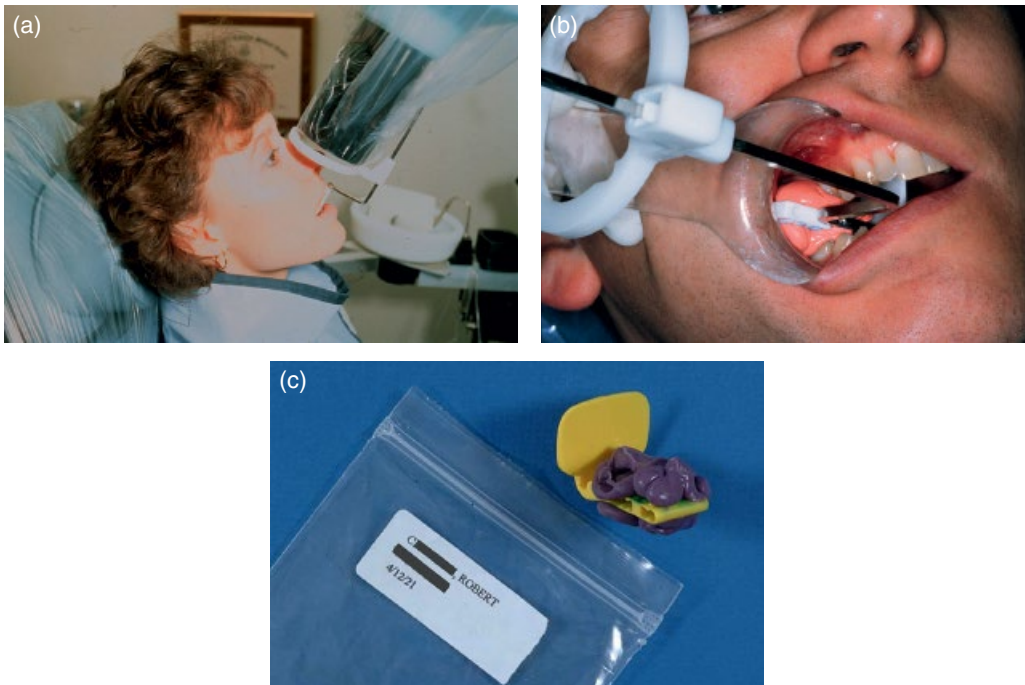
(a) All radiographs should be taken using holders which allow parallelism and standardization. (b) If comparative radiographs will be required on follow up, it is useful to fabricate a customized rubber bite-block using putty impression material. (c) The bite registration is then stored along with the film holder. Courtesy of Dr. Sigurdsson.
